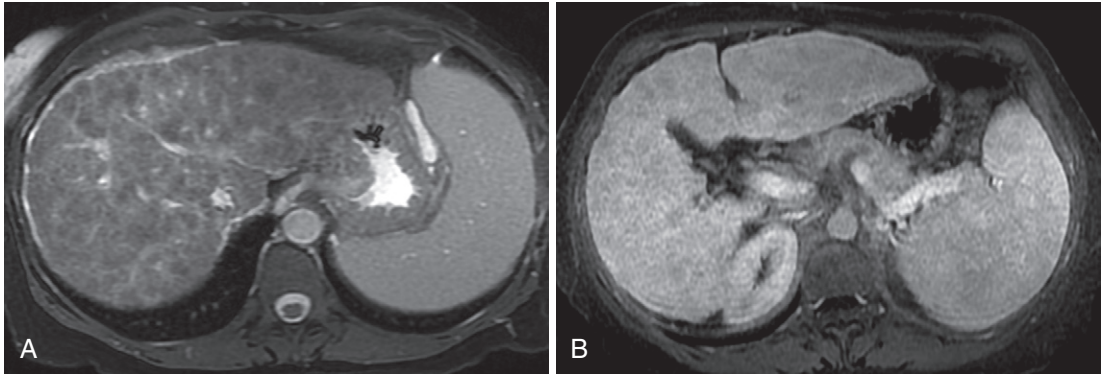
Regenerative nodules surrounded by fibrosis. A, Innumerable nodular islands of hepatic parenchyma are margined by bridging bands of hyperintensity on the moderately T2-weighted image in a very cirrhotic liver—the typical appearance of regenerative nodules with intervening reticular fibrosis. B, Delayed enhancement of the fibrotic bands surrounding the relatively hypointense nodules conjures a honeycomb appearance.
